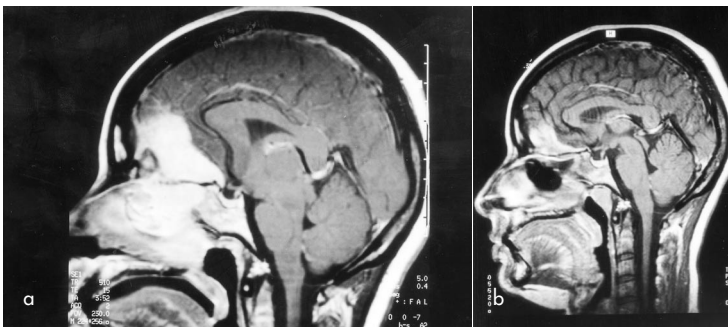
Sagittal SE T1 magnetic resonance imaging post gadolinium showing (a) extensive Aspergillus disease of paranasal sinuses, and through cribriform plate to frontobasal brain, (b) same view 7 months later after antifungal and immunomodulatory treatment.
